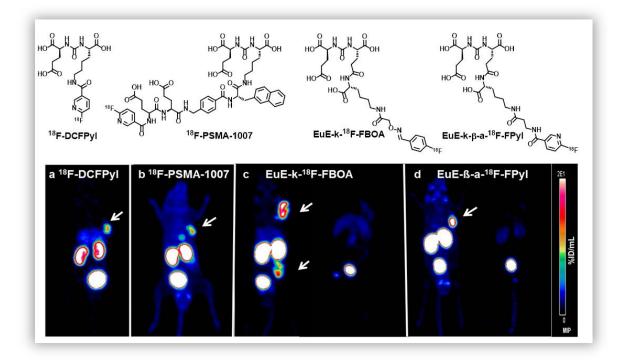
Comparative μ PET scans of (a) ¹⁸F-DCFPyI; (b) ¹⁸F-PSMA-1007 (c) left: EuE-k-¹⁸F-FBOA, right: + blocking with 8 mg/kg PMPA; (d) left: EuE-k- β -a-¹⁸F-FPyI, right: + blocking with 8 mg/kg (PMPA) (60-90 min p.i.; 0-20 % ID/mL; 0.9-1 MBq). Image modified from [314].
